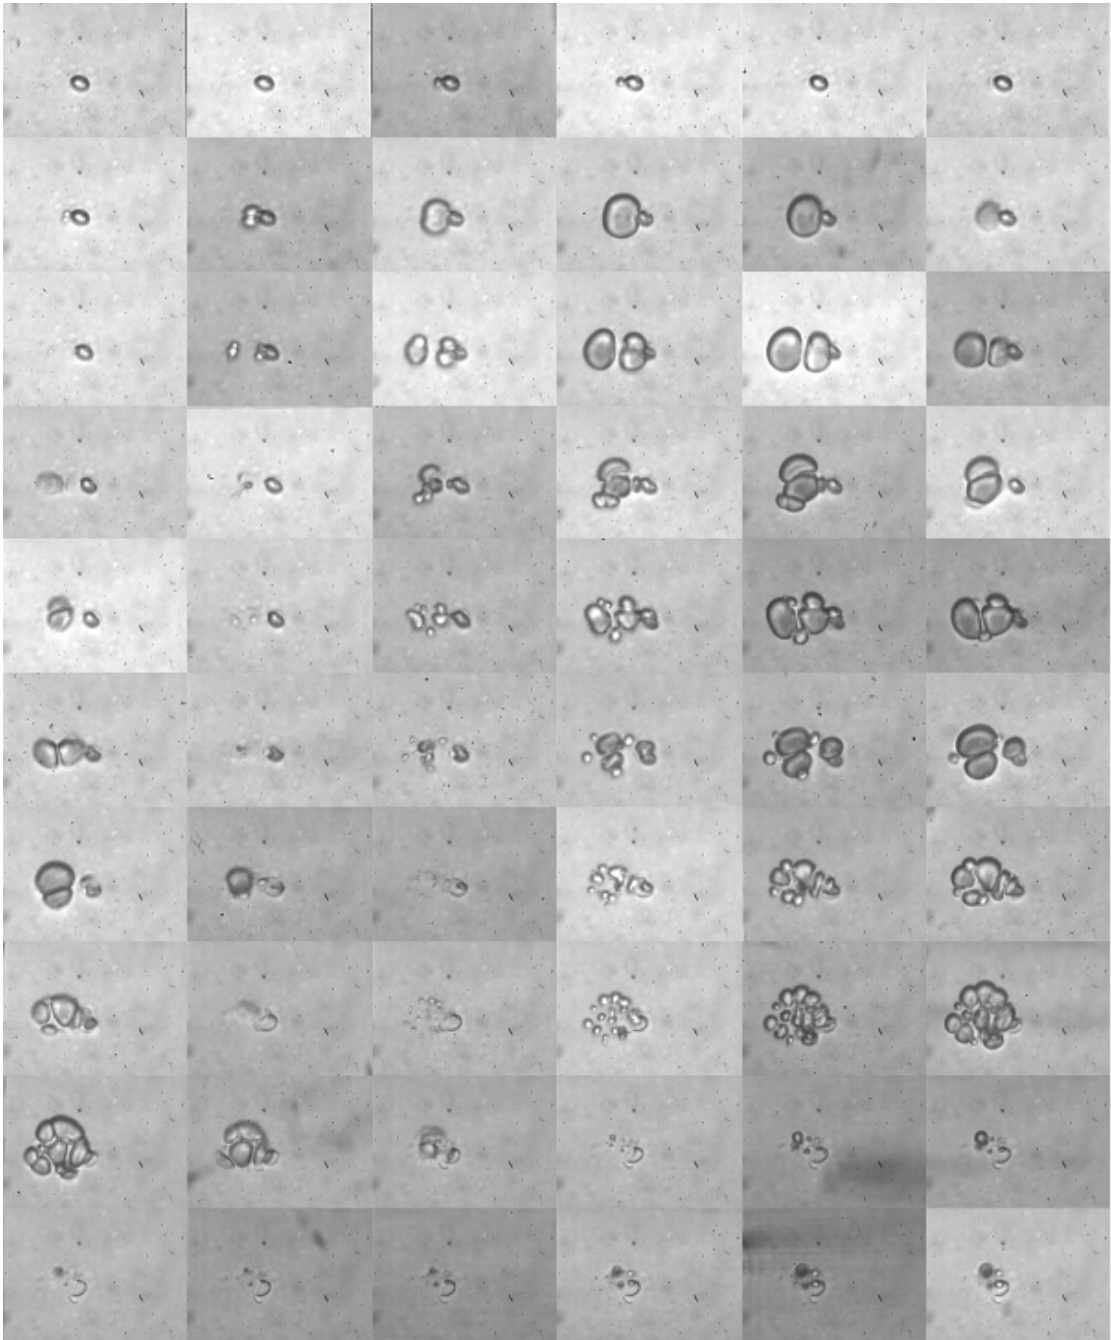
Single PLA microbubble oscillating and exploding under ultrasound.
